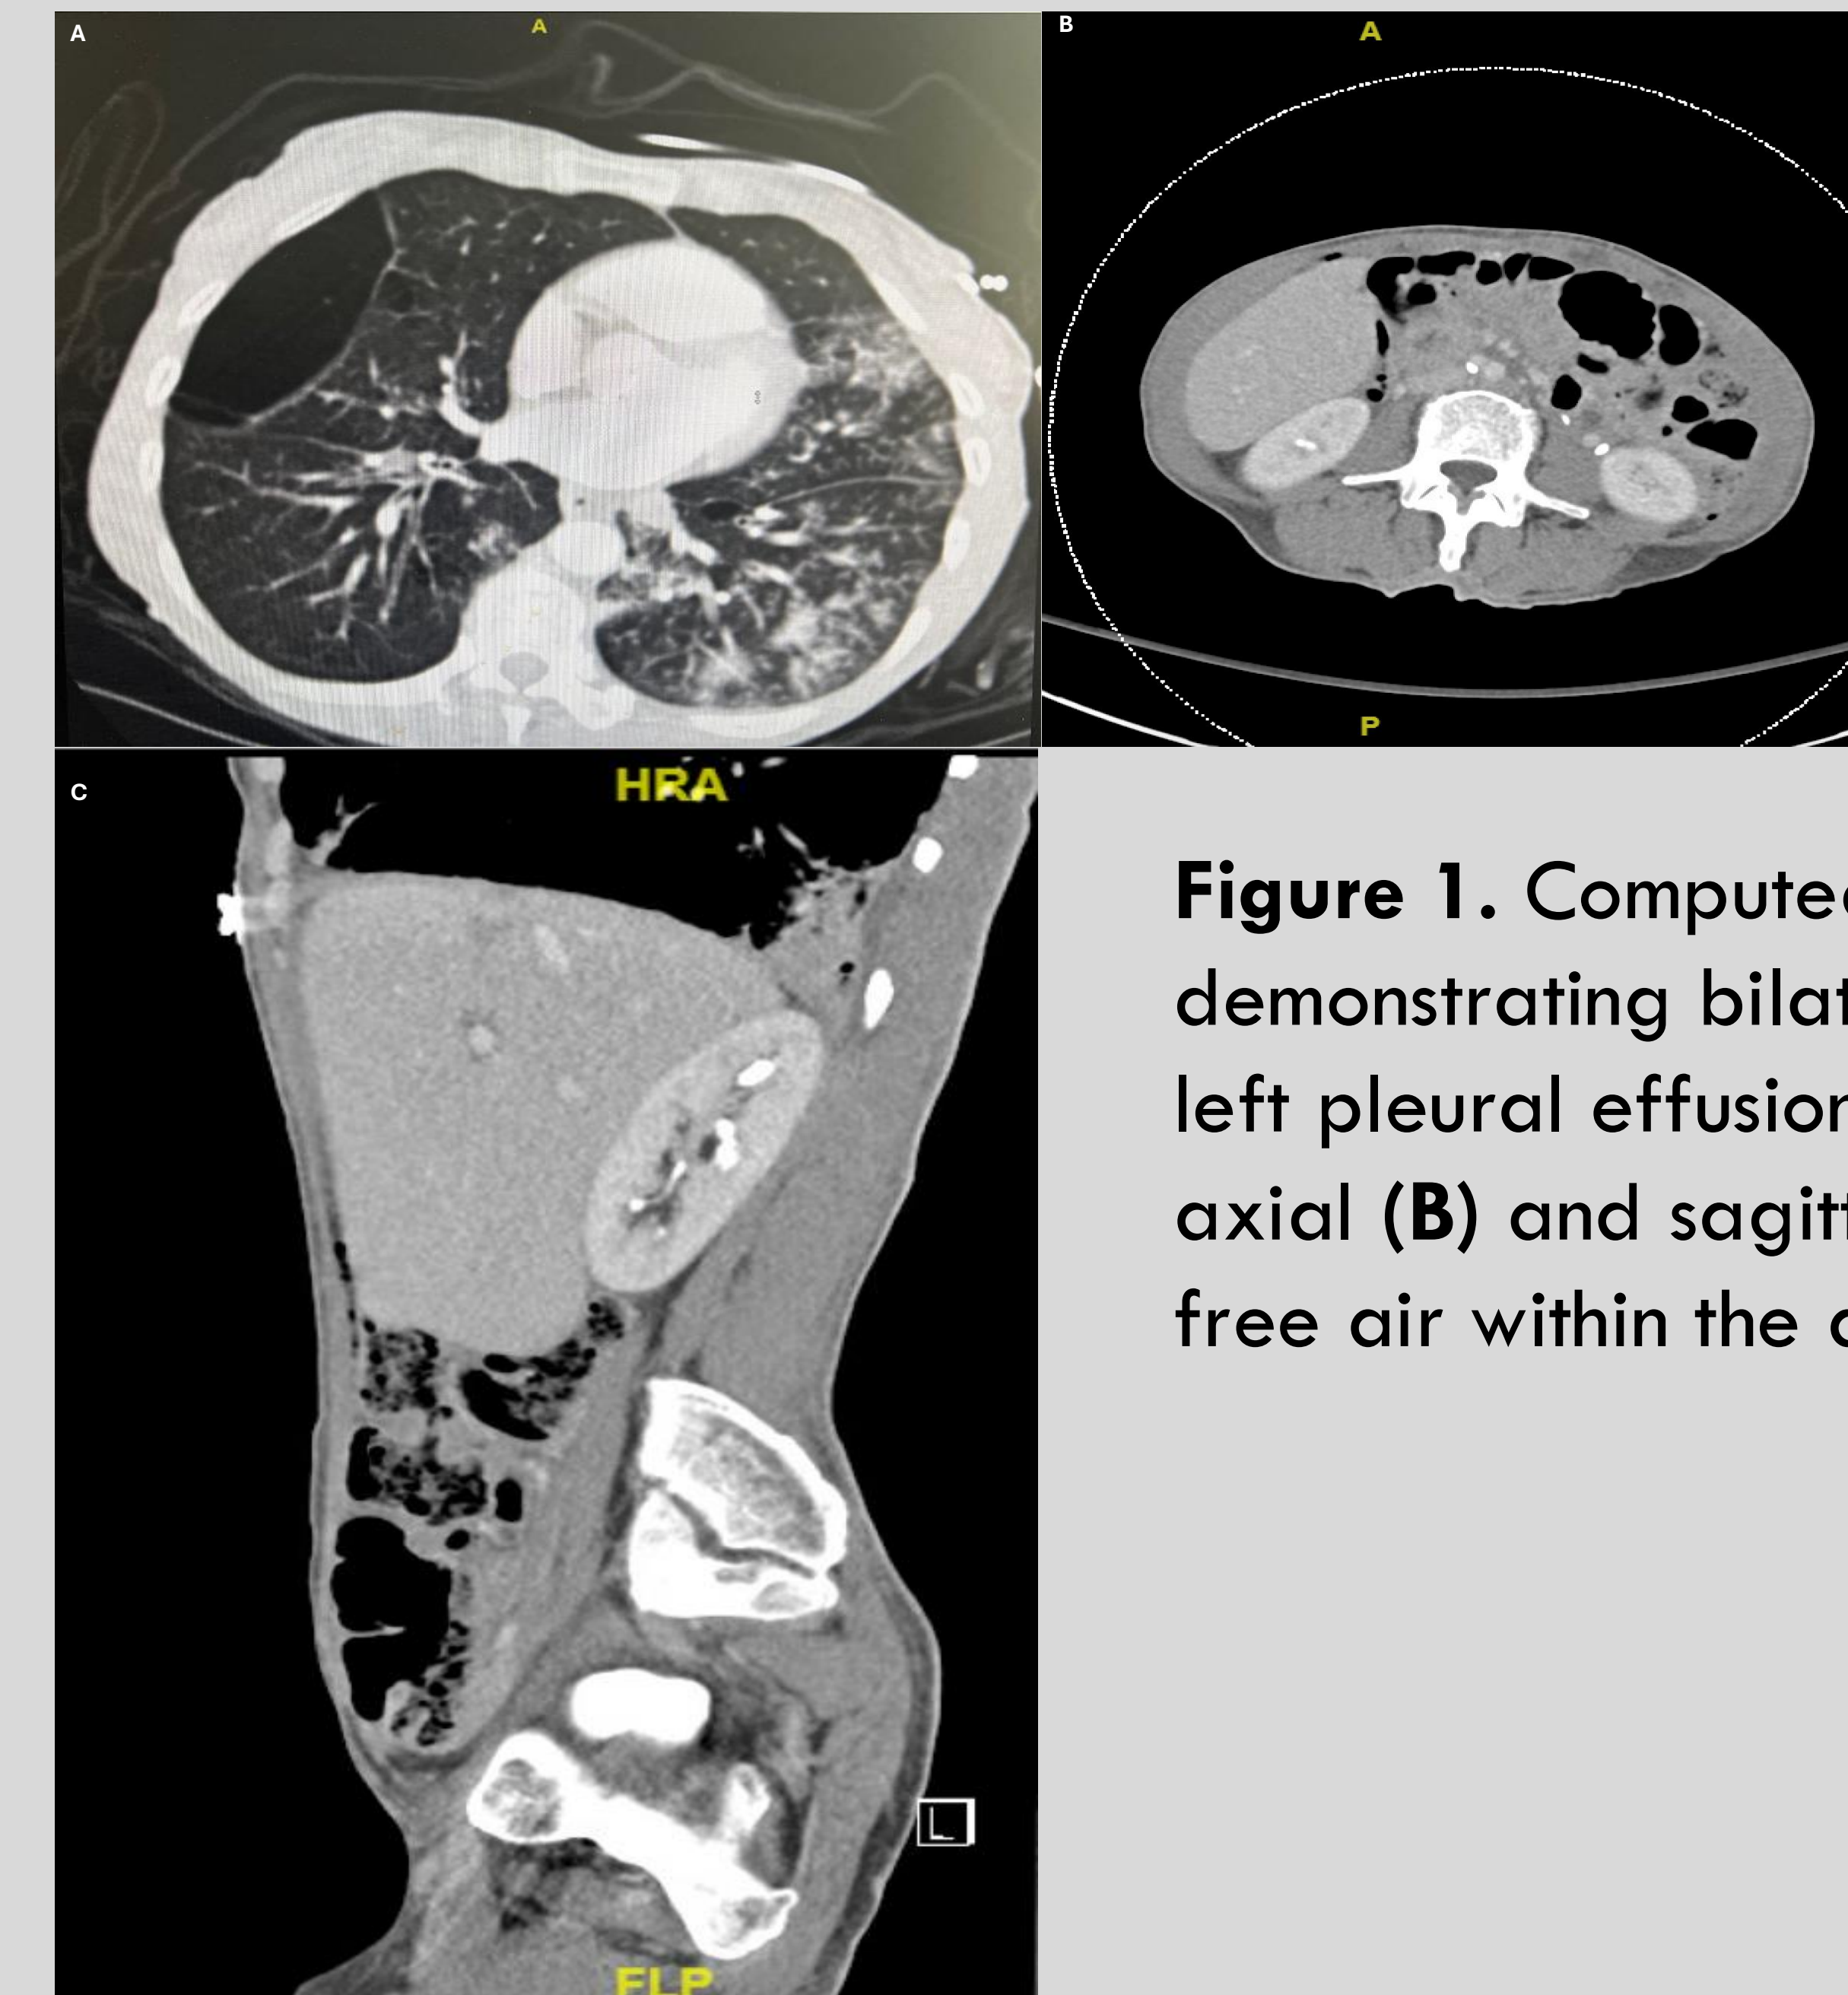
Computed tomography of the chest (A) demonstrating bilateral multifocal pneumonia and trace left pleural effusion along with abdomen and pelvis in axial (B) and sagittal (C) view demonstrating few foci of free air within the anterior peritoneal cavity.
